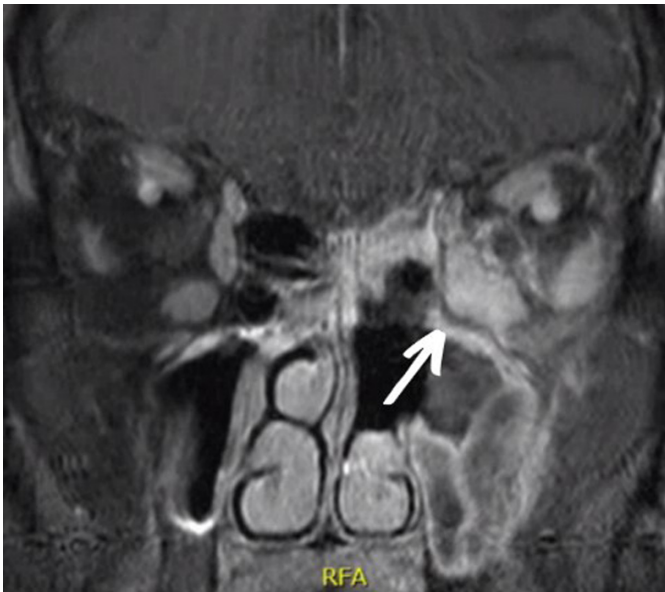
Contrast-enhanced T1-weighted magnetic resonance imaging showing an increased intraconal inflammation 7 days postoperatively.
